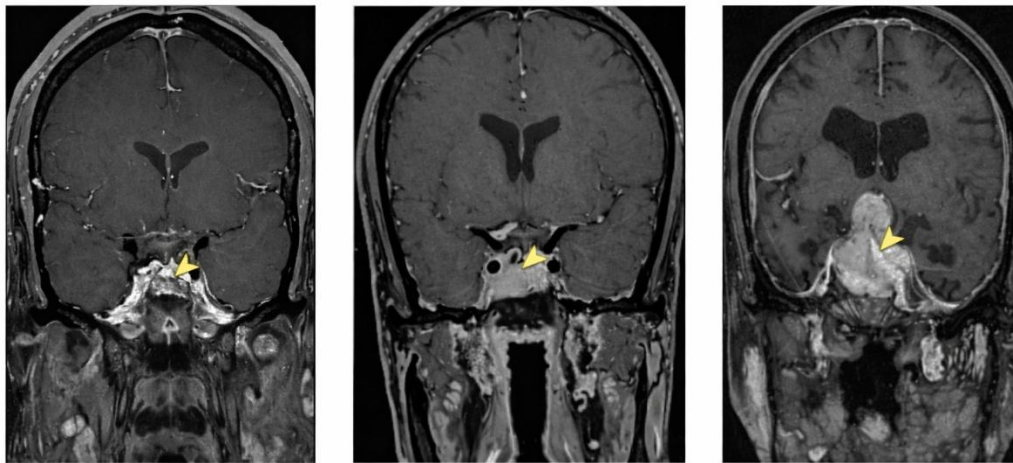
Magnetic Resonance Imaging of Pituitary Adenomas (Molitch, 2017).
